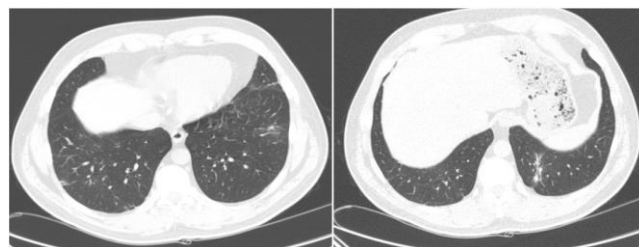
Control chest CT revealing regression of pulmonary hemorrhage and shrinkage of the pneumatoceles 24 days after the initial admission to hospital
